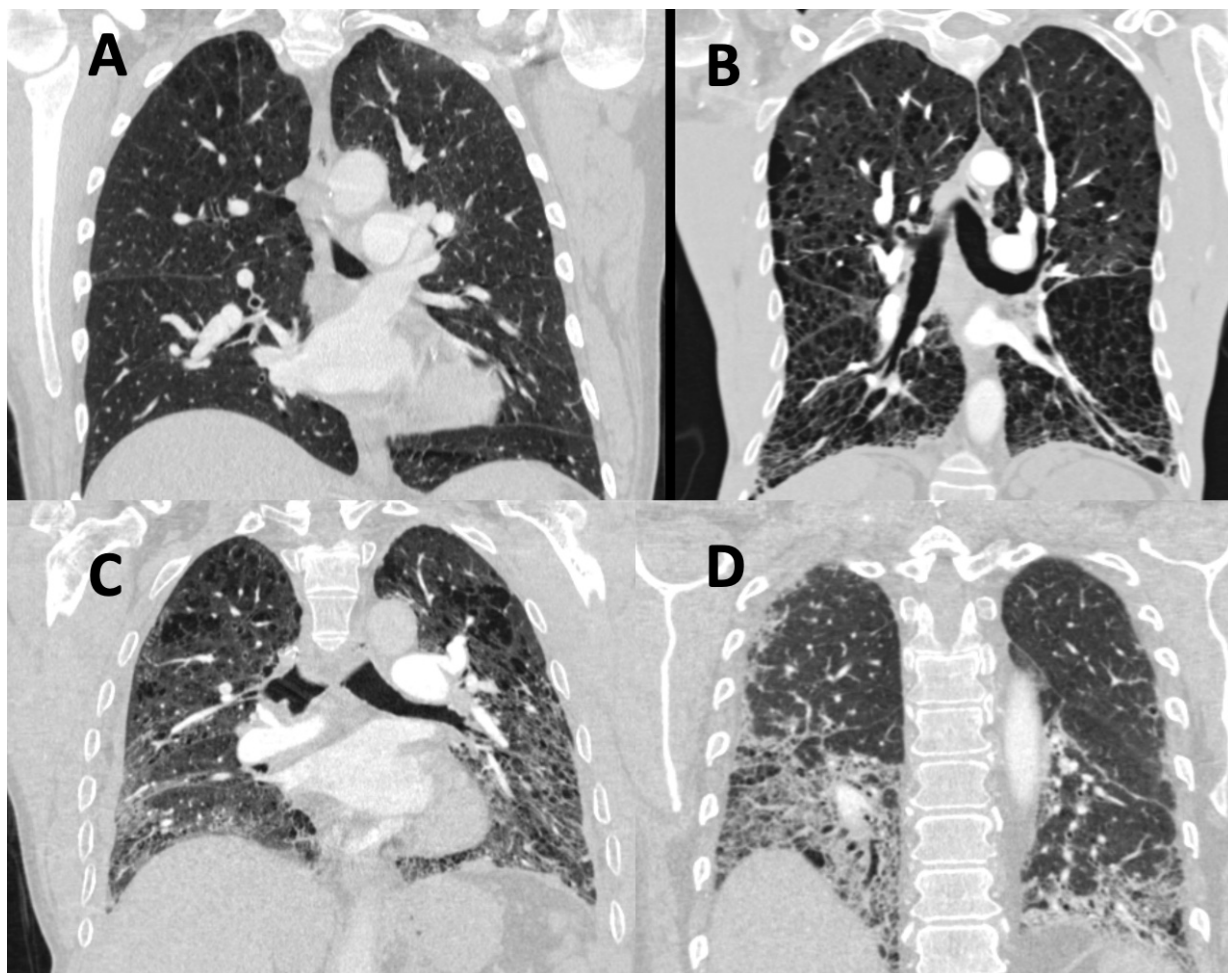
Patterns of lung disease in PH-Lung as visualised on CT. A - mild emphysema, localised predominantly to the upper lobe. B - widespread severe emphysema. C - combined emphysema and fibrosis. D - interstitial lung disease.
